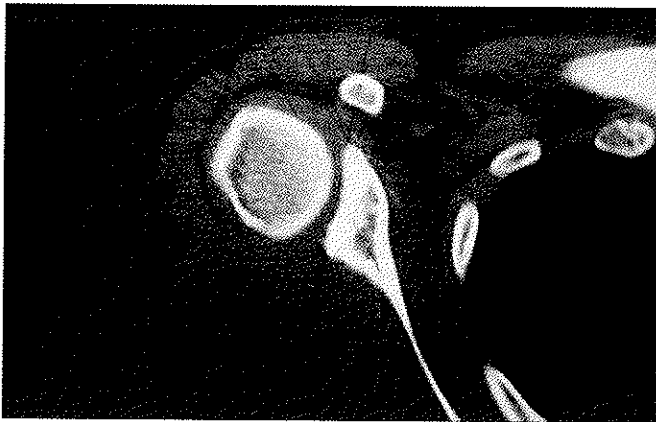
MRI showing glenoid dysplasia.
